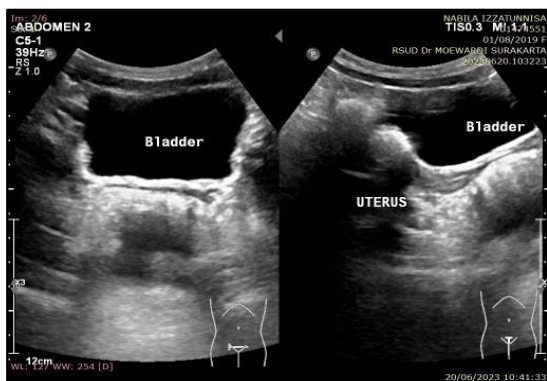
Genitalia ultrasonography.
